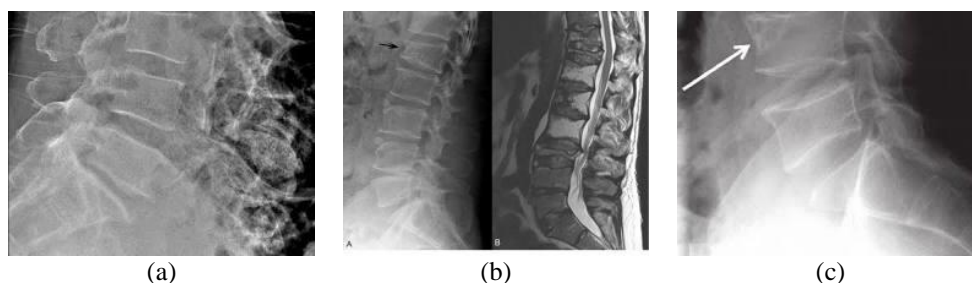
(a) This lateral spine X-ray exhibits normal bone density and vertebral structure, with no signs of fractures or significant degenerative changes, (b) This lateral spine X-ray demonstrates osteopenia, characterized by reduced bone density compared to the normal image. The vertebral bodies appear slightly less opaque and the trabecular pattern is less distinct. (c) This lateral spine X-ray shows a compression fracture in the L1 vertebra, indicated by the wedged shape and loss of height of the vertebral body.
